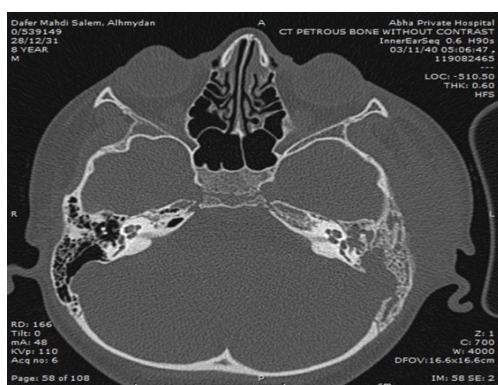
CT scan of the petrous bone, without contrast, showing complete opacification of the left mastoid air cells and left middle ear cleft
